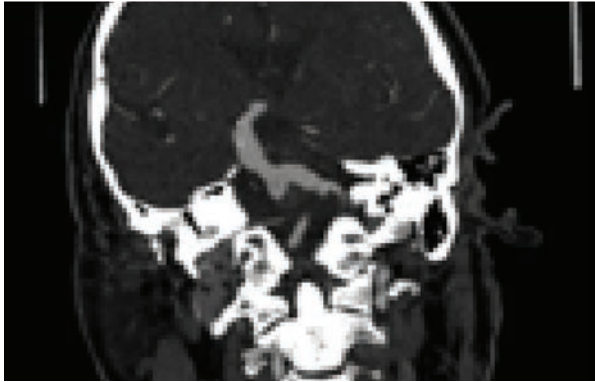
CTA of patient 2.
